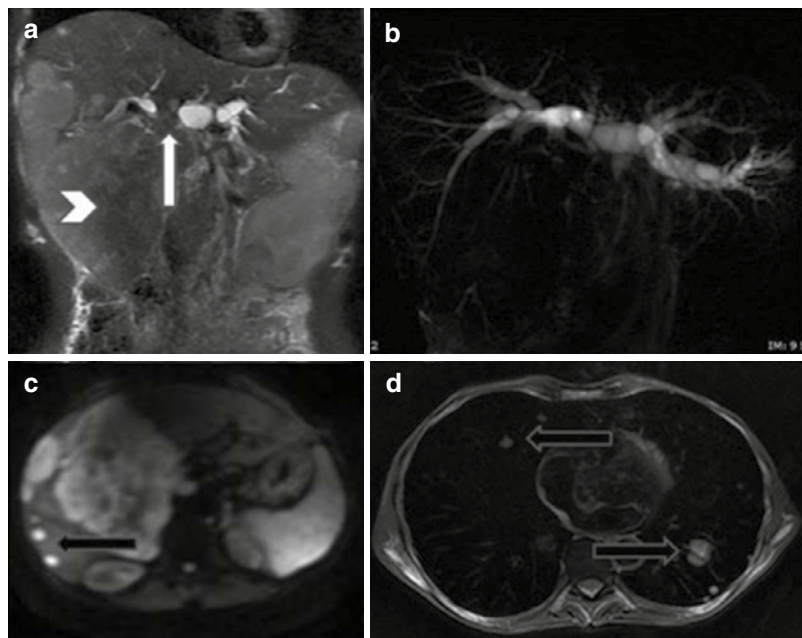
A case of advanced carcinoma of the gallbladder: (a, b) Coronal T2WI and thick-slab 2D MRCP images reveal a large mass replacing the gallbladder with surrounding hepatic infiltration (arrowhead) and extension to the hilar region (white arrow) with resultant hilar block and attendant moderate upstream biliary dilatation. (c, d) DWI and axial T2WI reveal hepatic and pulmonary metastases (black arrows)
